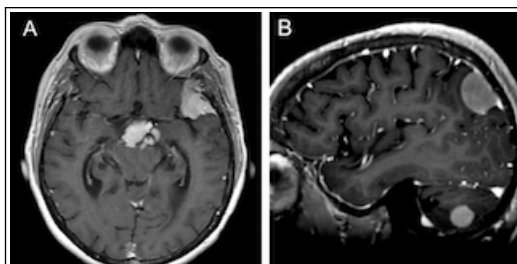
Case examples of multiple meningiomas in patients with a history of fertility treatment. Post-contrast T1-weighted MRI two different patients in the series. Axial (A) shows a patient with a left lateral sphenoid wing and large clival meningioma extending above the dorsum, and sagittal (B) shows a patient with a parietal convexity and cerebellar convexity.
